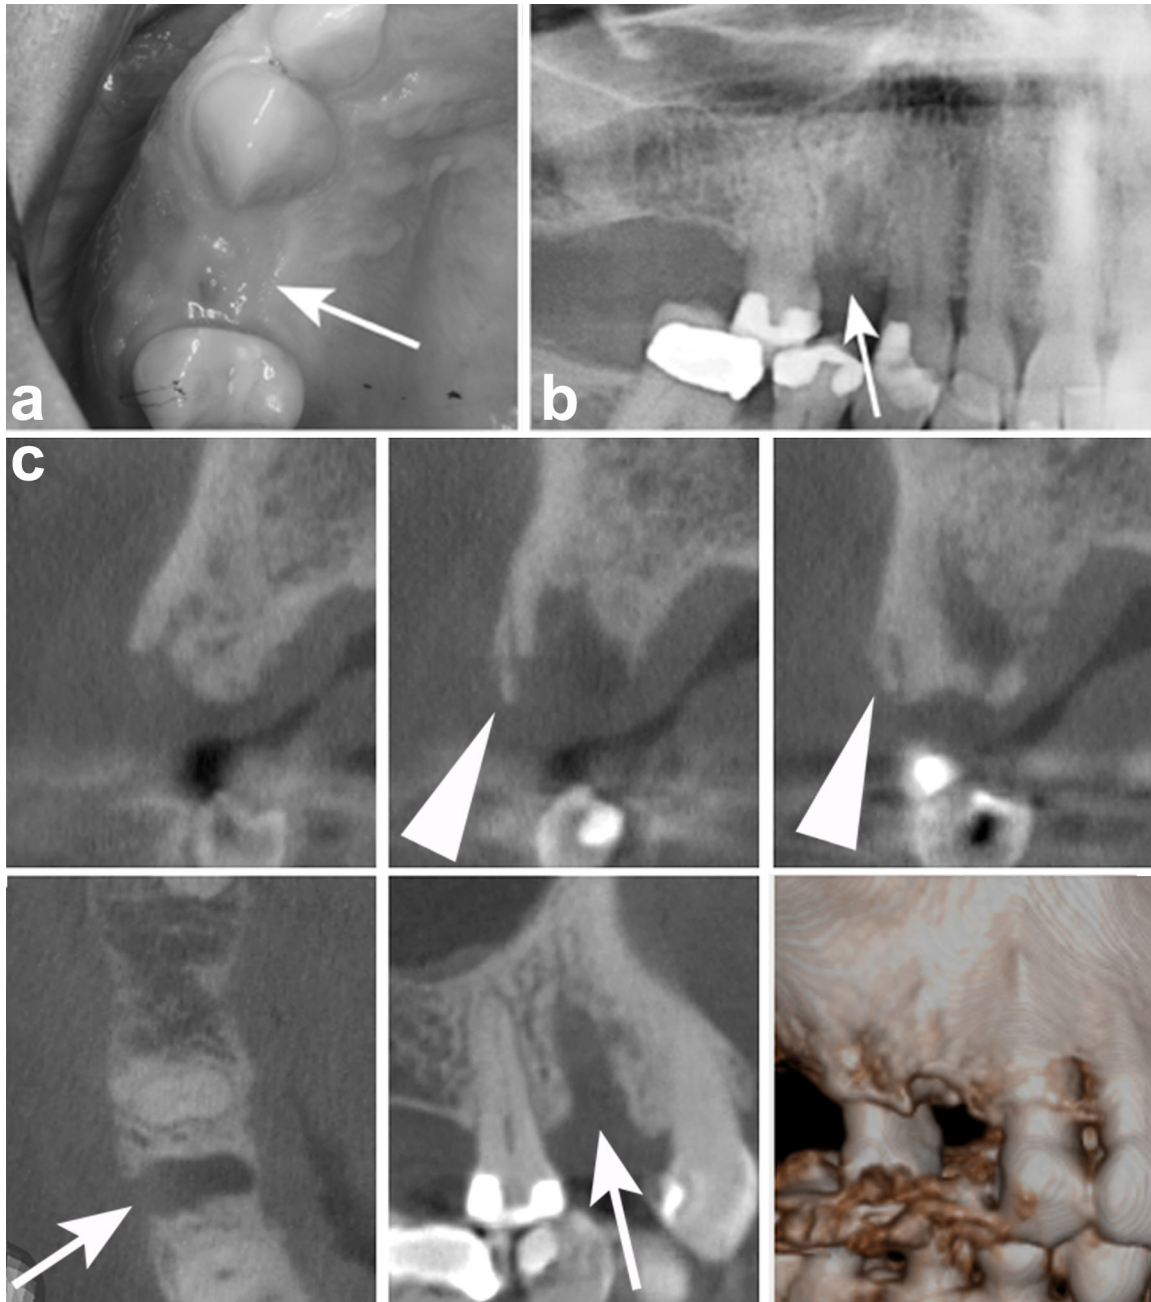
Example of provided material for each patient: (a) clinical photograph, (b) panoramic radiograph (c) CBCT images of the area of interest. Arrows point to the extraction area of 14. Arrow heads point to possible sequestration of the buccal cortex of the maxilla in the area of 14. CBCT, cone beam CT.
